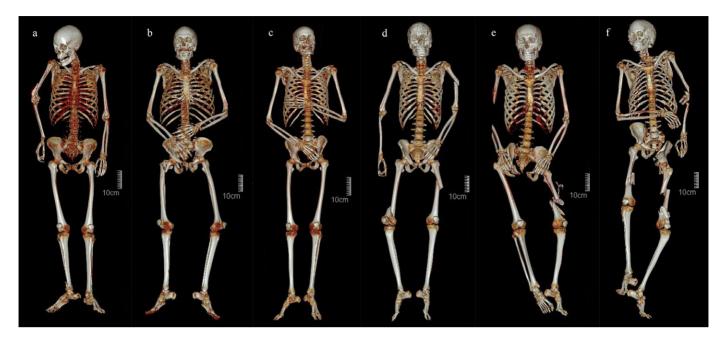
Examples of skeletal polytrauma resulting from fatal high falls. The PMCT scans show volume rendered anterior views of the full skeleton from falls of 9 m (a), 12 m (b), 12 m (c), 24 m (d), 63 m (e), and 84 m (f) onto nondeformable surfaces. NB: in cases d, e, and f, aspects of the elbows and lateral forearms were outside the CT FOV and subsequently could not be investigated for possible skeletal fractures. [Color figure can be viewed at wileyonlinelibrary.com]
